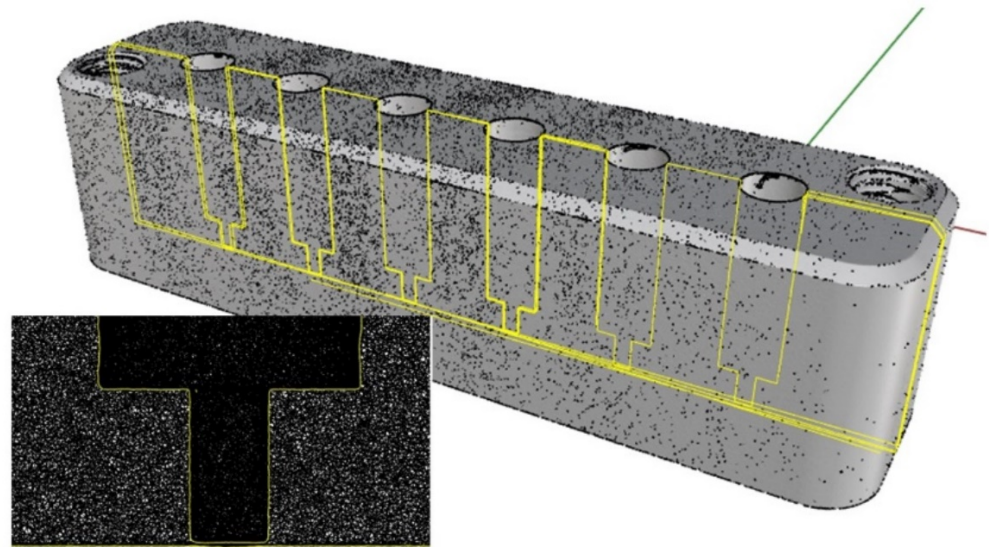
An X-ray CT of one of the mould inserts used in this work. The insert shows an enlarged image showing the thin "window" are at the base of each blind hole
